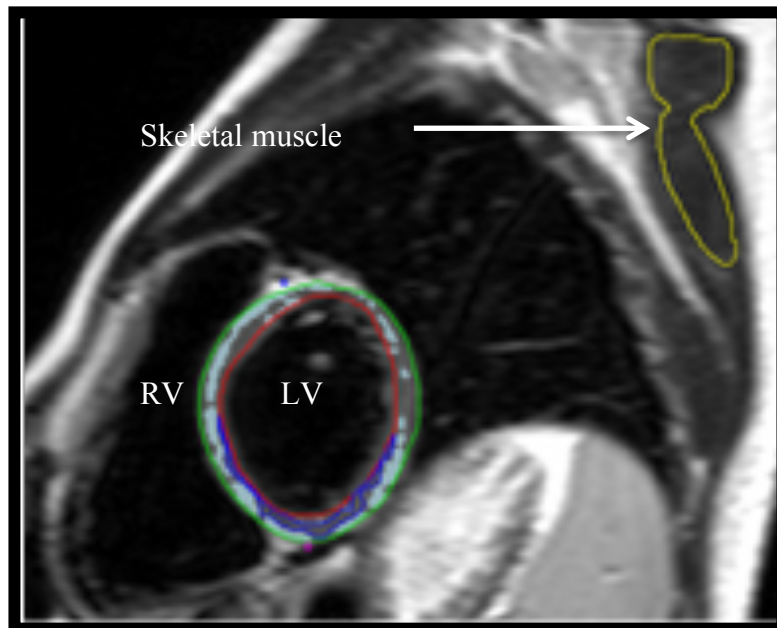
T2-weighted short axis images were evaluated for oedema using computer-aided analysis. The areas of oedema were colour coded according to its signal intensity.
